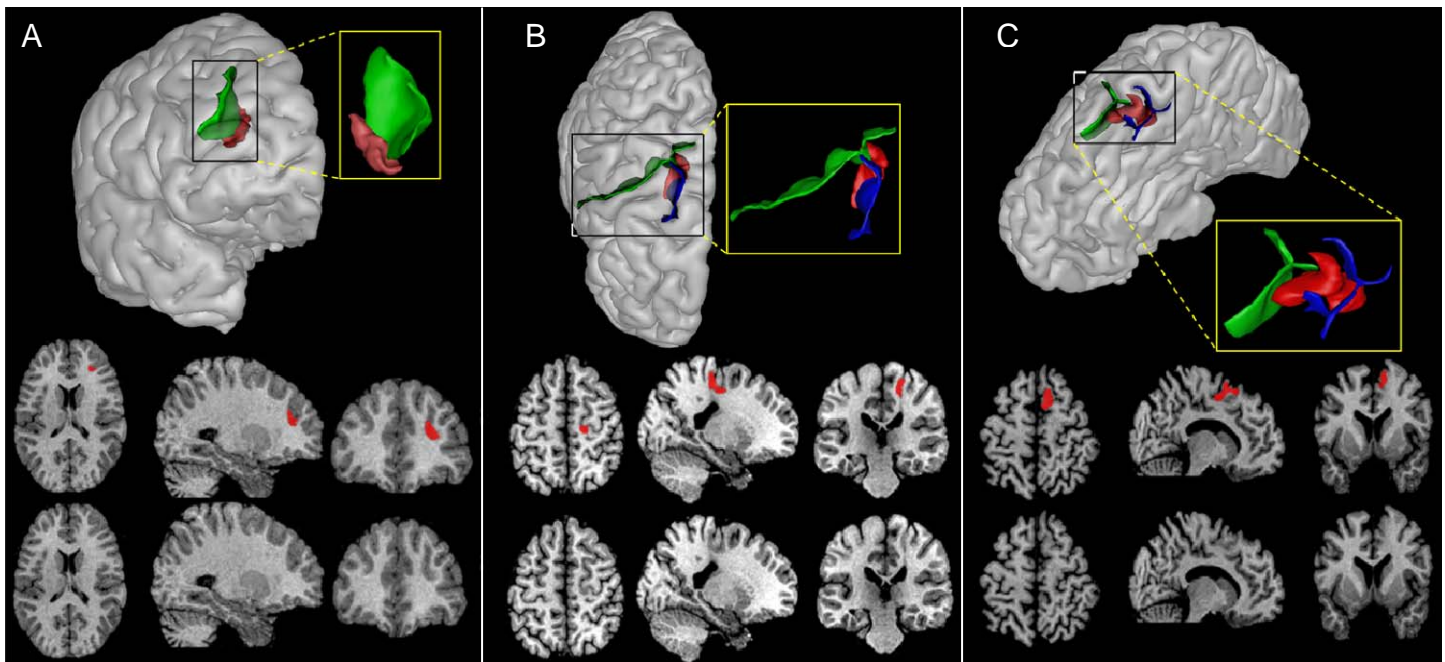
Top row: 3D surface reconstruction with overlaid sulci (green). The FCD is colored in red. Sulci related to the FCD are magnified in separate panels. Three examples are shown: A) FCD at the bottom of a sulcus; B) FCD at the bottom of two sulci; C) FCD related to the walls of several sulci. Bottom rows: T1-weighted MR images (axial, sagittal and coronal) overlaid with the FCD label.
